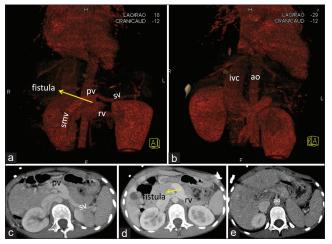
Reconstructed volume rendered technique images (panel a and b) and contrast enhanced computed tomography images in axial section at the level of splenoportal axis (panel c-e) showing fistulous communication between portal vein and left renal vein. No evidence of intrahepatic portal venous radicles seen. SV: Splenic vein, Ao: Aorta, SMV: Superior mesenteric vein, IVC: Inferior vena cava
